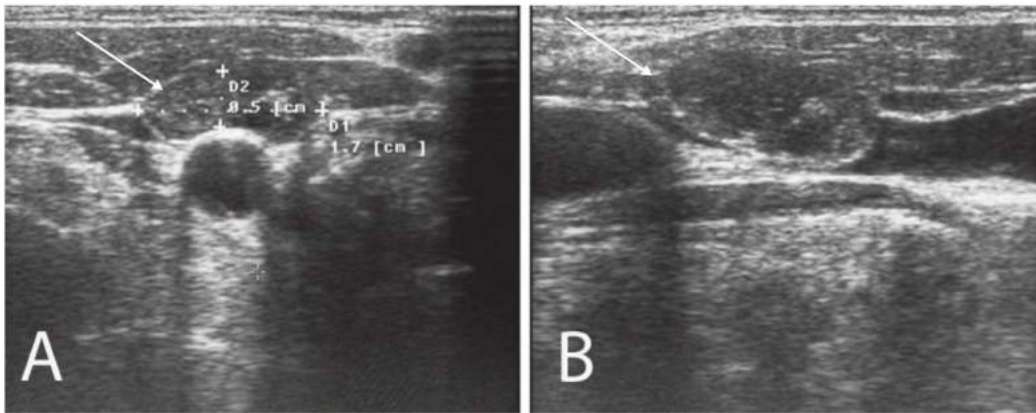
• Ultrasound demonstration of metastatic lymph nodes in thyroid cancer. Panel A shows a transverse view (*arrow*), and panel B shows the longitudinal view (*arrow*).
